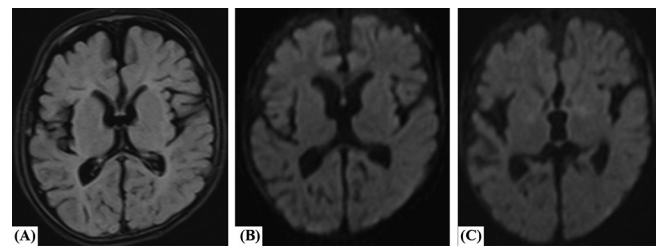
FLAIR (A) and diffusion weighted images (B,C) of the brain done after 6 weeks shows resolution of diffusion abnormalities with mild generalized cerebral atrophy.
